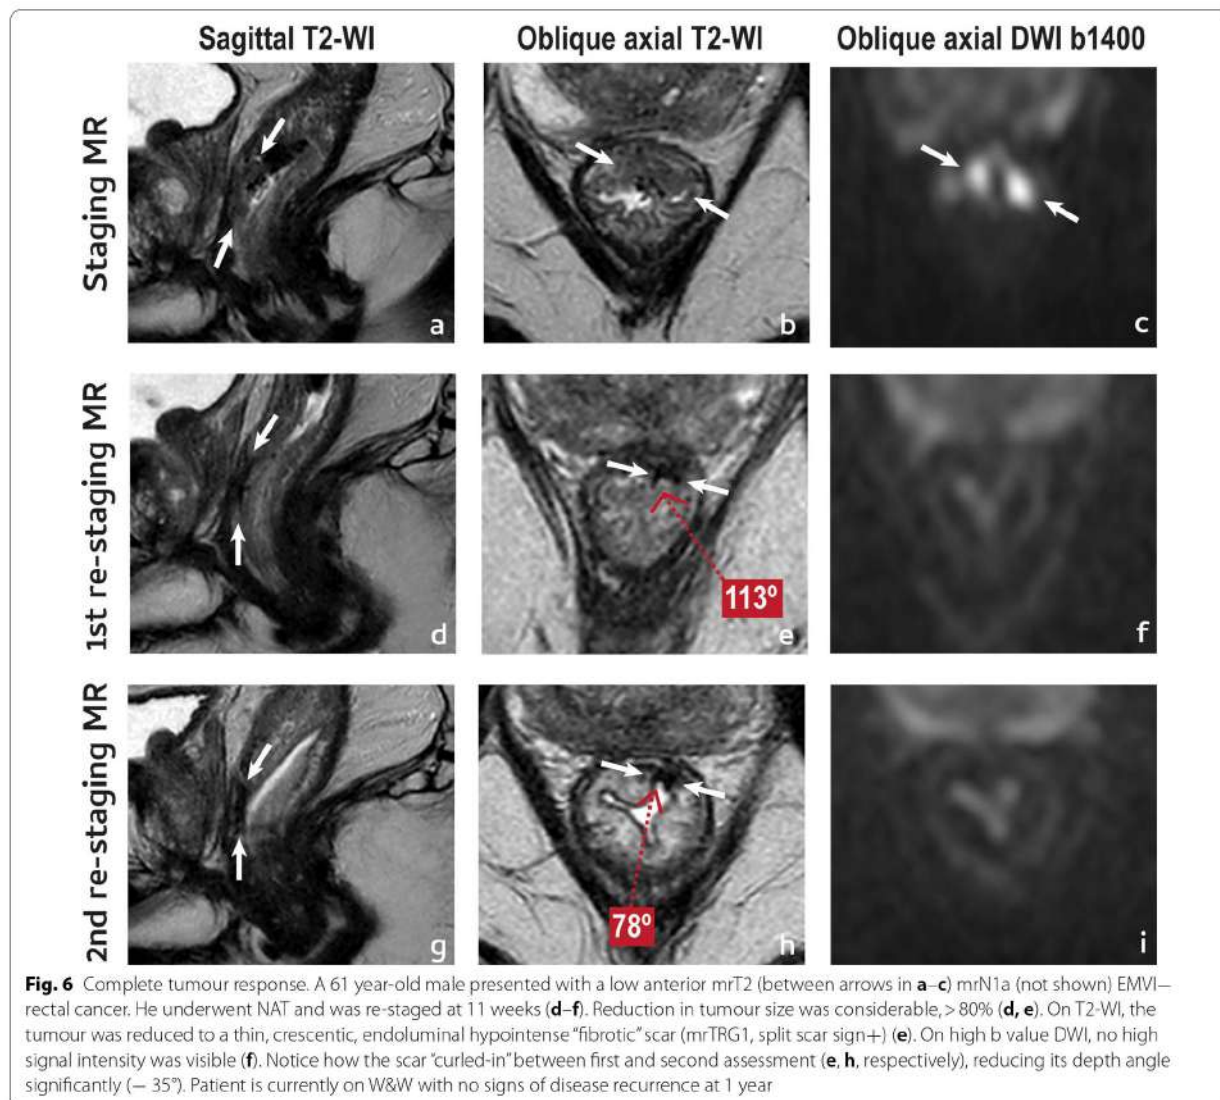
Complete tumour response. A 61 year-old male presented with a low anterior mrT2 (between arrows in a–c) mrN1a (not shown) EMVI-rectal cancer. He underwent NAT and was re-staged at 11 weeks (d–f). Reduction in tumour size was considerable, > 80% (d, e). On T2-WI, the tumour was reduced to a thin, crescentic, endoluminal hypointense “fibrotic” scar (mrTRG1, split scar sign+) (e). On high b value DWI, no high signal intensity was visible (f). Notice how the scar “curled-in” between first and second assessment (e, h, respectively), reducing its depth angle significantly (– 35°). Patient is currently on W&W with no signs of disease recurrence at 1 year
